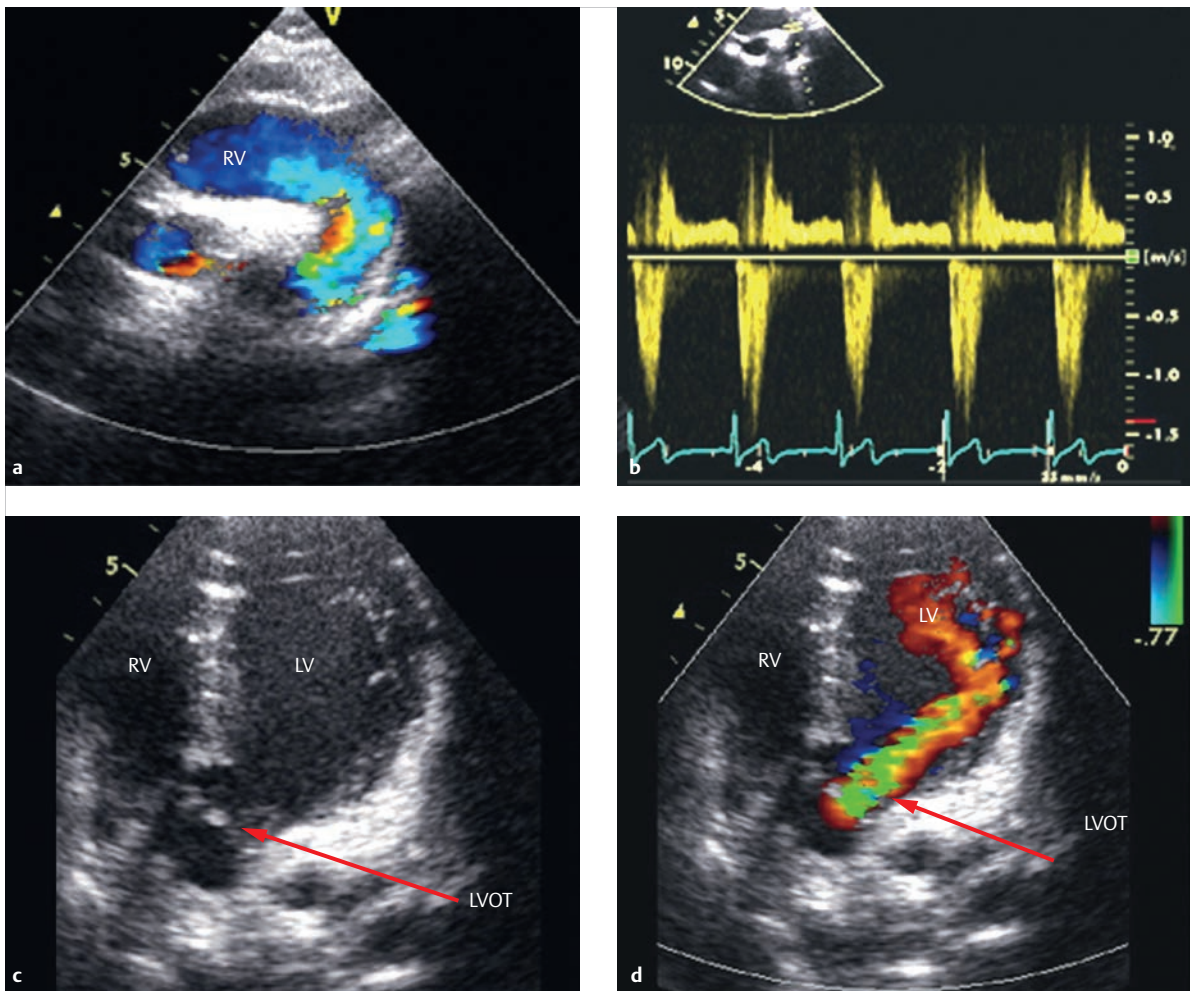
Condition after surgical correction of type A₂ (type II) common arterial trunk. Ten-year-old female patient after surgical correction of type A₂ (type II) common arterial trunk (the same patient as in ► Fig. 4.96). Both color Doppler (a) and spectral Doppler (b) show holodiastolic regurgitation in the extracardiac conduit equipped with a pulmonary valve. The 5-chamber view depicts pronounced, extensive holodiastolic regurgitation (c, d, arrows) near the trunk valve in the aortic position. The dotted lines in e and f each indicate the position of the MRI through-plane flow measurement in the conduit and cranial to the trunk valve. A diastolic dephasing jet can even be seen caudal to the trunk valve using SSFP cine MRI (f), due to the pronounced “aortic valve insufficiency.” MRI flow measurement resulted in a regurgitation fraction of 35% of antegrade flow (h, light blue area, pulmonary valve insufficiency). Near the conduit, the regurgitation fraction was 15% of antegrade flow (g, light blue area, aortic valve insufficiency).
